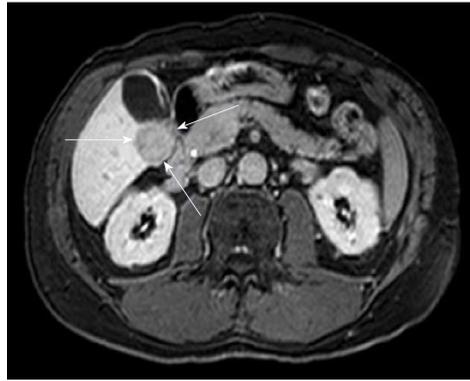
Magnetic resonance imaging (e-THRIVE_BH AX 15 min delay) of 61-yr-old male with hepatitis C virus, without cirrhosis showing a 2.8 cm × 3 cm mass lesion in segment 5 consistent with hepatocellular carcinoma.
